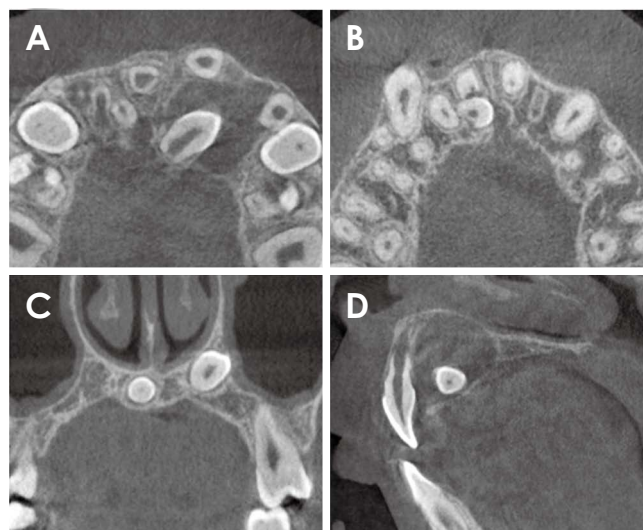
Cone-beam computed tomographic images of mesiodens-related complications. A. Cyst surrounding left mesiodens cause the displacement of anterior teeth. B. Root resorption of permanent maxillary right central incisor. Note the direct contact between the mesiodens with both the affected tooth and nasopalatine canal. C. Perforation of left maxillary sinus is caused by migrated left mesiodens. D. Abnormal root formation of permanent maxillary central incisor is seen.
